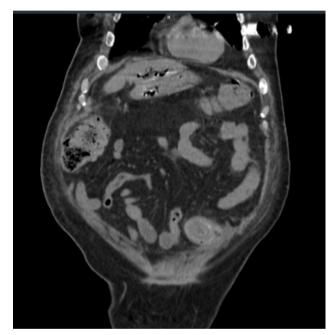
Coronal plane abdominal computed tomography (CT) scan demonstrating a gallstone in the sigmoid colon.
